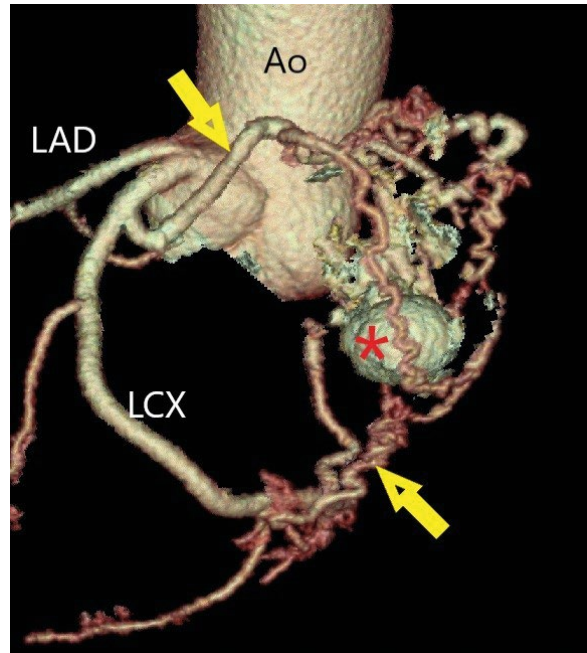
Coronary computed tomography reconstruction. Image shows ascending aorta and coronary tree. It presents domination of left coronary artery and separate origins of left anterior descending (LAD) and left circumflex (LCX) arteries from the left aortic sinus. Two enlarged branches of LCX (yellow arrows) feed the vascular part of the mass (red asterisk). No significant coronary artery disease is noted; Ao — aorta.
